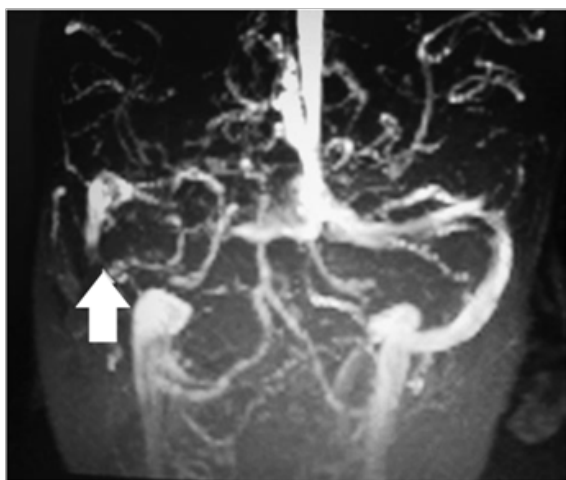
MRI venography showing (arrow) absence of flow in the right lateral sinus.
